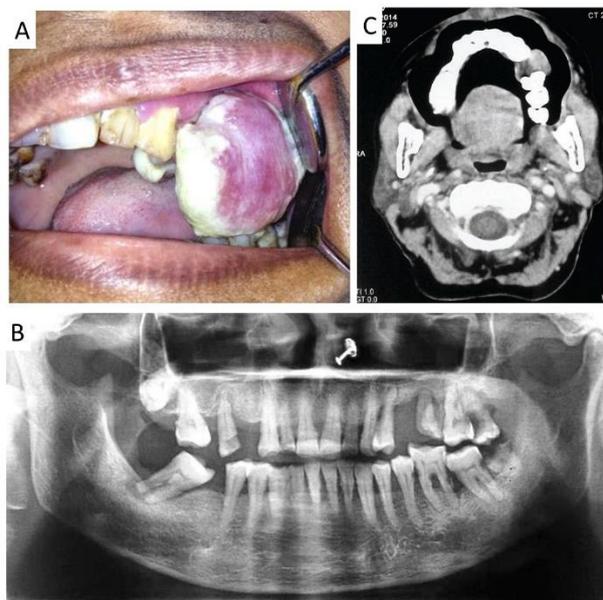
A) Growth in the left posterior maxillary region; B) Orthopantomogram showing a soft tissue shadow on the left maxillary posterior region with severe bone loss; C) Contrast computer tomography scan exhibiting the extensiveness of the lesion
